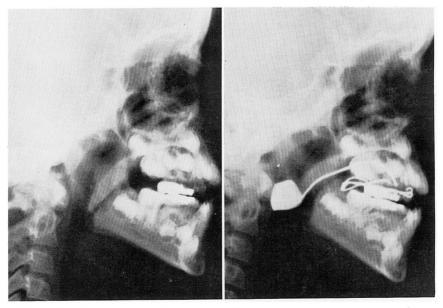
(left). Lateral radiograph of child with palatal incompetence prior to obturation.
